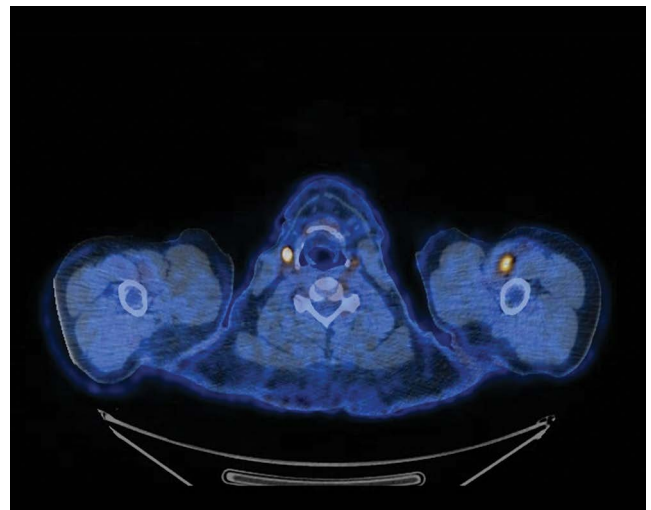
PET/CT axial fusion projection performed under TSH stimulation — accumulation of the [18F]FDG in the right cervical lymph node
